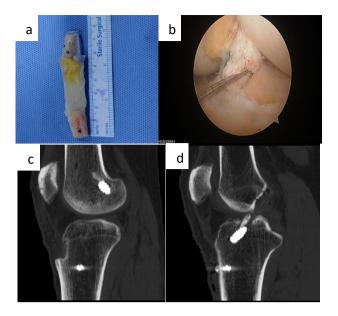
(a) Intraoperative photo of short BPTB graft 72 mm. (b) Arthroscopic image showing reconstructed ACL using BPTB graft. (c) Sagittal CT scan showing proximal graft migration. (d) Sagittal CT scan showing intraarticular bone plug migration.
